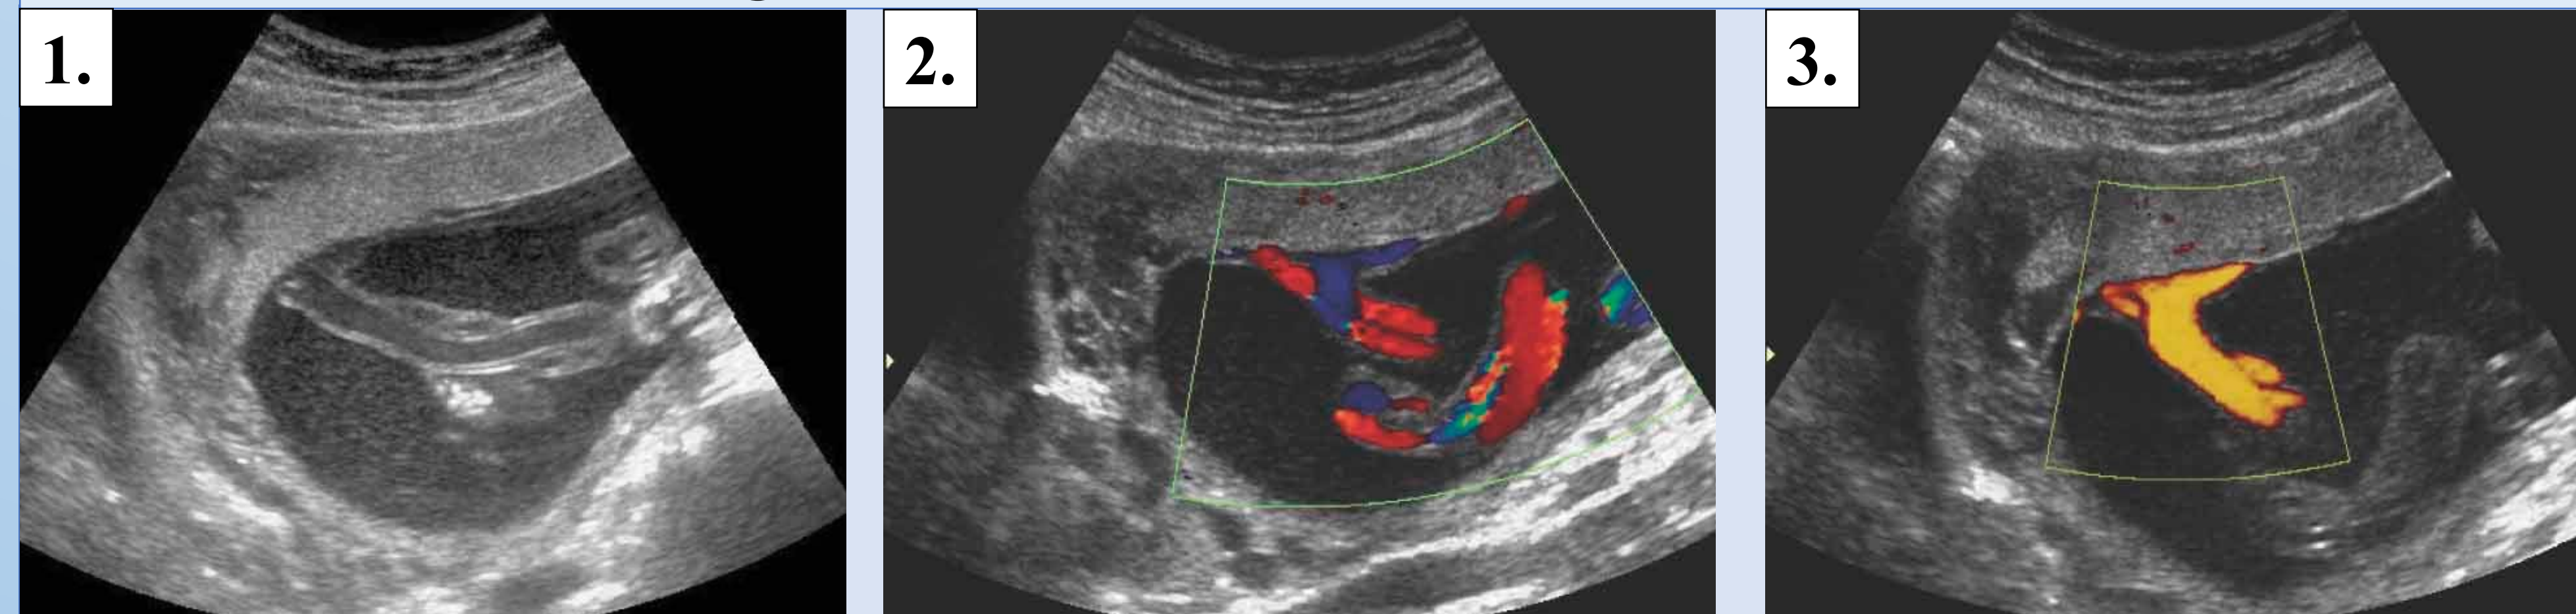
Ultrasound Examination of VCI<sup>7</sup>
